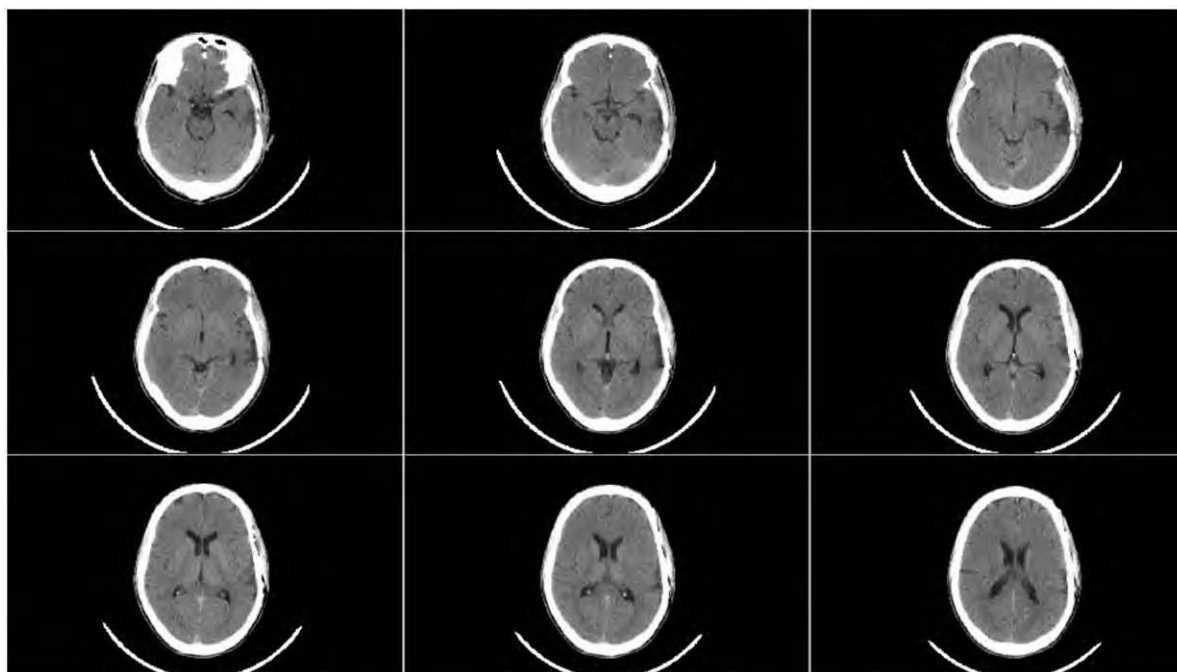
Conventional CT of Mr B's head depicting contusions to the left temporal lobe and portions of the left parietal lobe.
